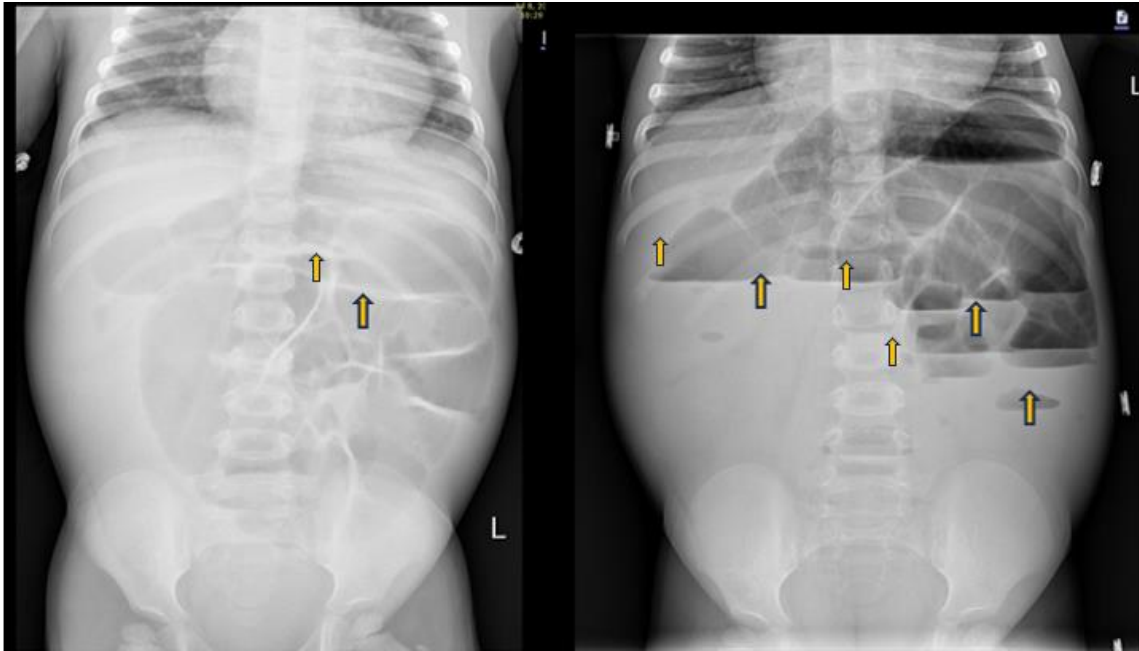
Abdominal X-ray in Supine and Erect position showing dilated small bowel loops and multiple air-fluid levels on admission.
